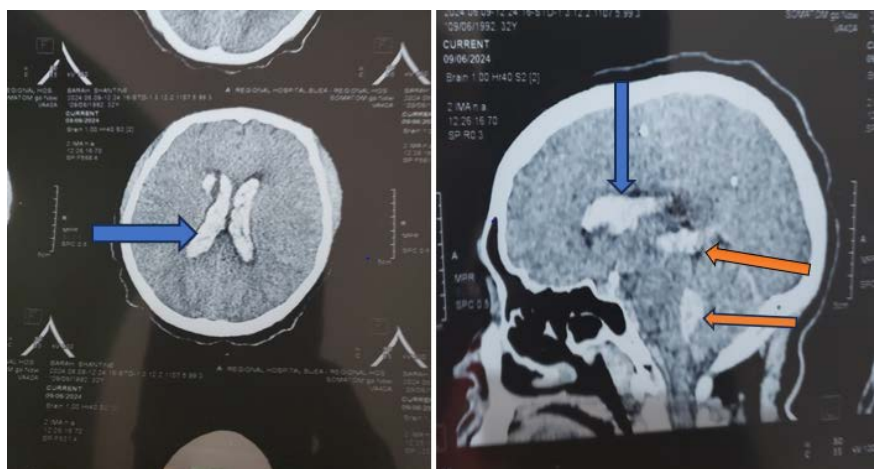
Axial and Sagittal views of Cerebral CT scan showing haemorrhage in all 4 ventricles. Blue arrows: Lateral ventricles, orange arrows: 3rd and 4th ventricles.
